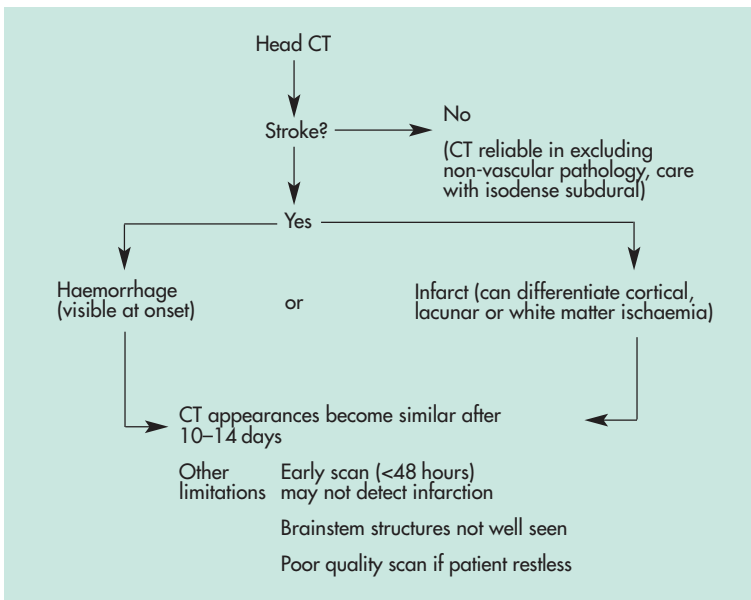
Contribution and limitations of head computed tomography (CT) in acute stroke.
